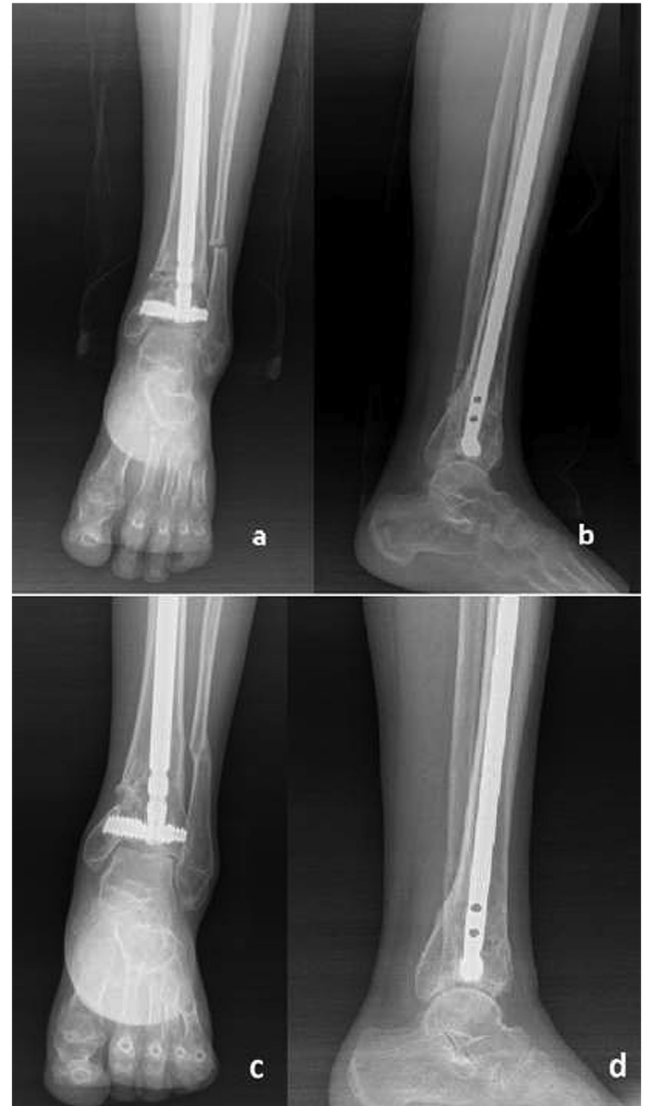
Early postoperative AP (a) and lateral (b) and final follow-up (postoperative 3 years) AP (c) and lateral (d) X-rays of Patient 3.
